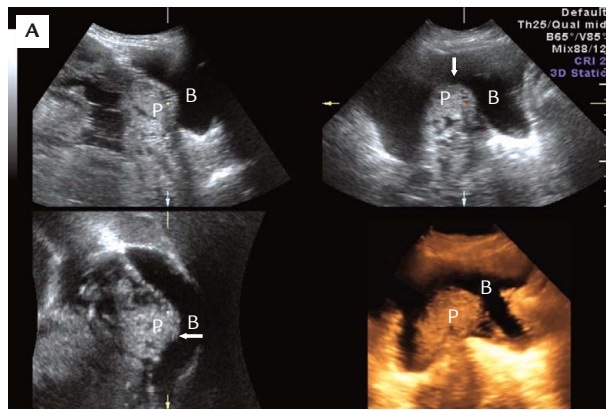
(A) Conventional two-dimensional ultrasound shows bulging uterine margin-bladder wall interface with multiple placental lakes. AF=amniotic fluid; BL=bladder; PL=placenta. (B) Multiplanar images show the densely adherent placenta invading the superficial bladder wall (arrow), but no actual extension into the bladder mucosa. B=bladder; L=lacunae; P=placenta.
